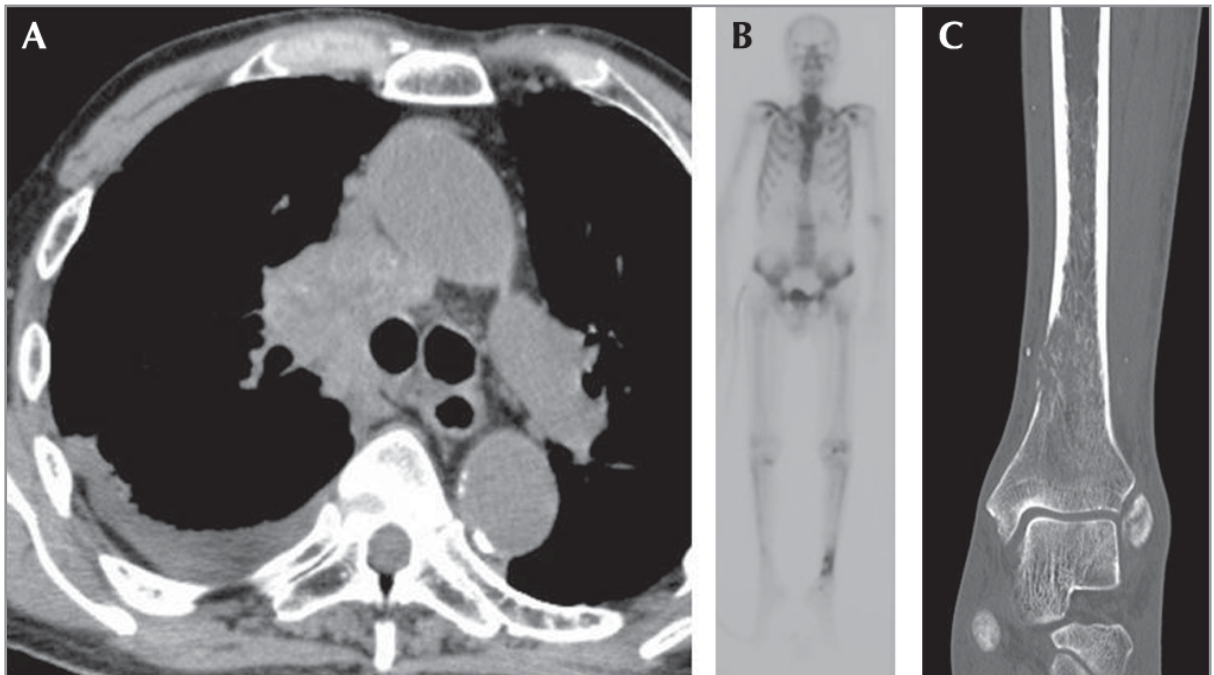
Chest CT scan showed a mass with ipsilateral hilar and mediastinal lymph node swelling and pleural fluid (A). 99Tc-MDP bone scintigram (B) and CT scan (C) showed solitary tibia metastasis.
